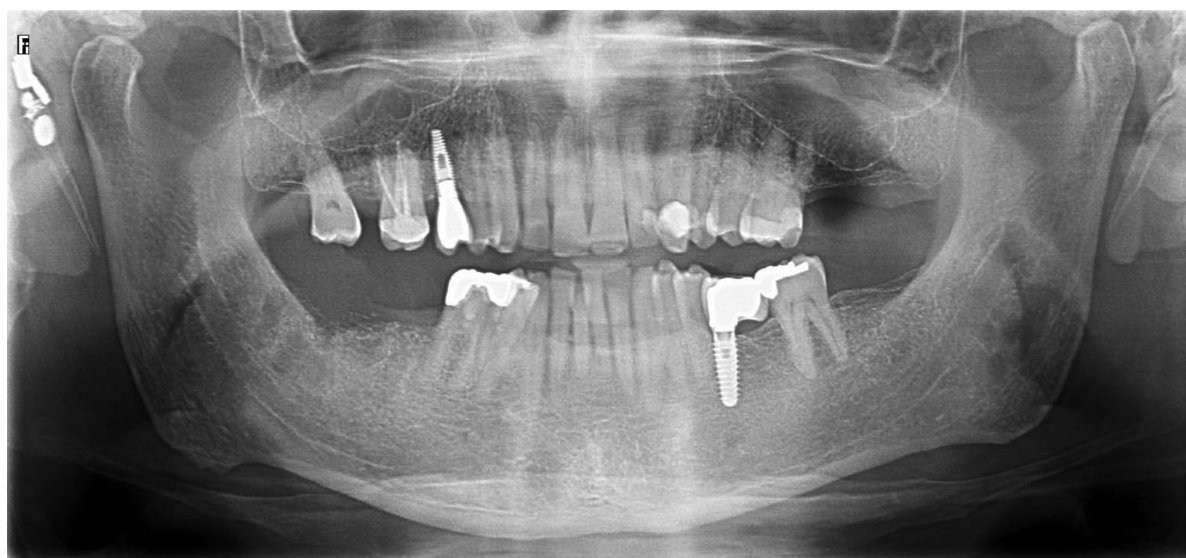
Orthopantomography after 4 days of procedure
